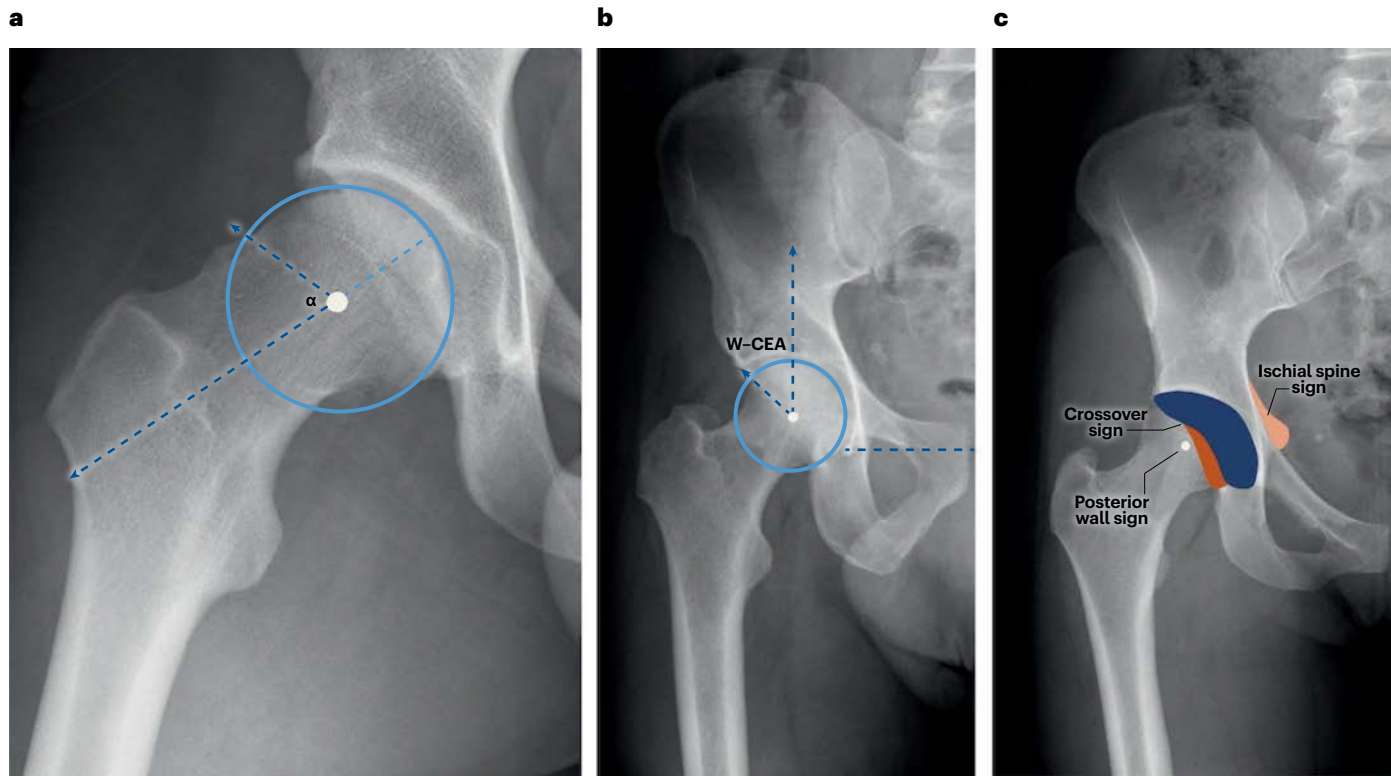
Cam morphology and pincer morphology. a. Cam morphology of the right hip, defined by an alpha angle $\alpha \geq 60^\circ$, as visualized on a Dunn 45° lateral radiograph. b. Global pincer morphology of the right hip, indicated by a centre-edge angle of Wiberg (W-CEA) $\geq 40^\circ$, on an anteroposterior pelvis radiograph.
